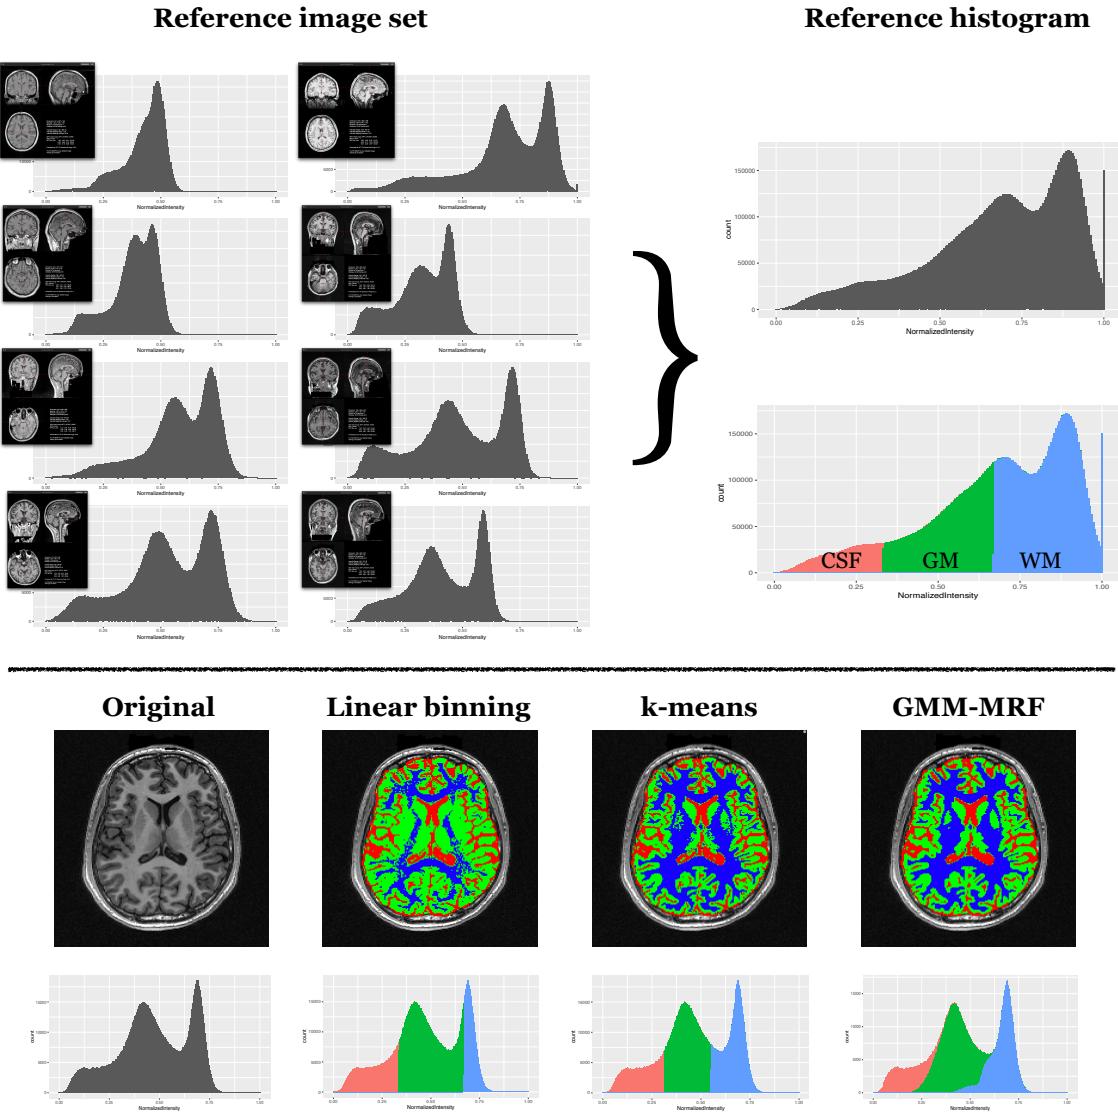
T1-weighted three-tissue brain segmentation analogy. Placing the three segmentation algorithms (i.e., linear binning, k-means, and GMM-MRF) in the context of brain tissue segmentation provides an alternative perspective for comparison. In the style of linear binning, we randomly select an image reference set using structurally normal individuals which is then used to create a reference histogram. (Bottom) For a subject to be processed, the resulting hard threshold values yield the linear binning segmentation solution as well as the initialization cluster values for both the k-means and GMM-MRF segmentations which are qualitatively different.
